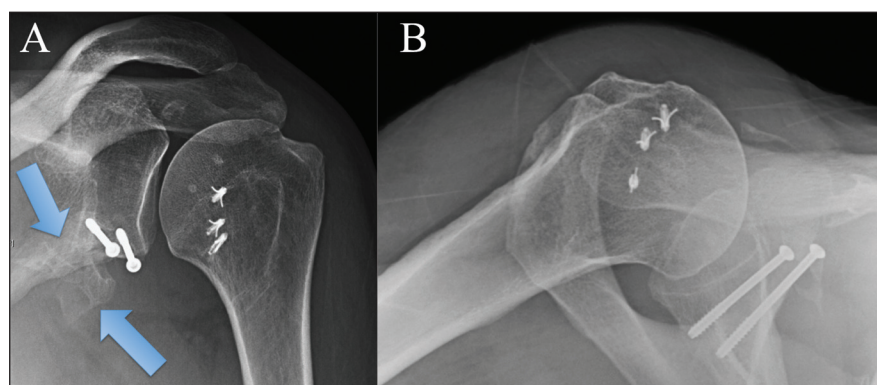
Preoperative anteroposterior radiograph of the left shoulder showing the medialized coracoid bone graft (blue arrows) and the 2 screws along with 3 previous anchors in the humeral head (A). Preoperative axillary radiograph showing slight anterior translation of the humeral head in relation to the glenoid (B).
